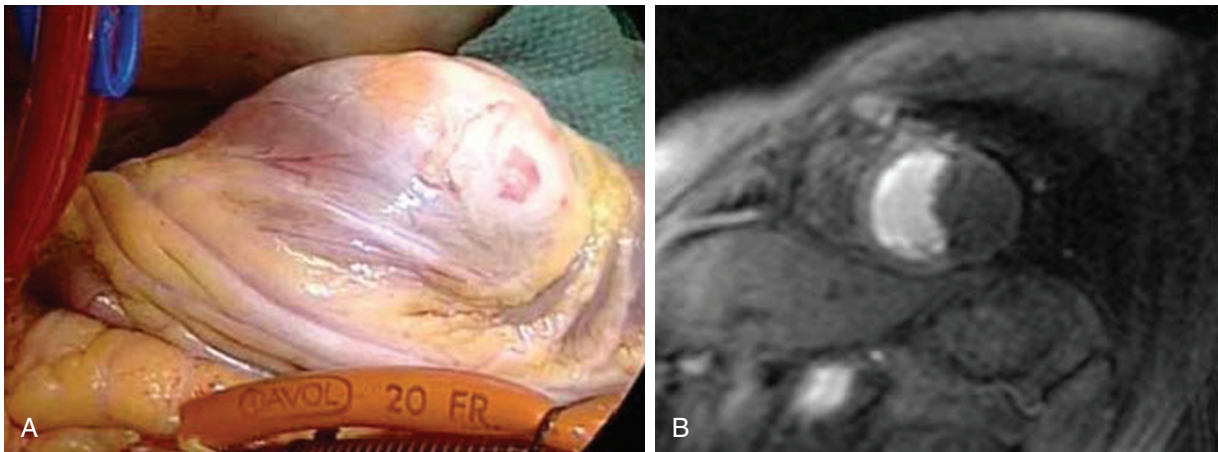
■ Fibroma. A, Heart showing left ventricular fibroma. B, Cardiac magnetic resonance imaging showing left ventricular fibroma.
